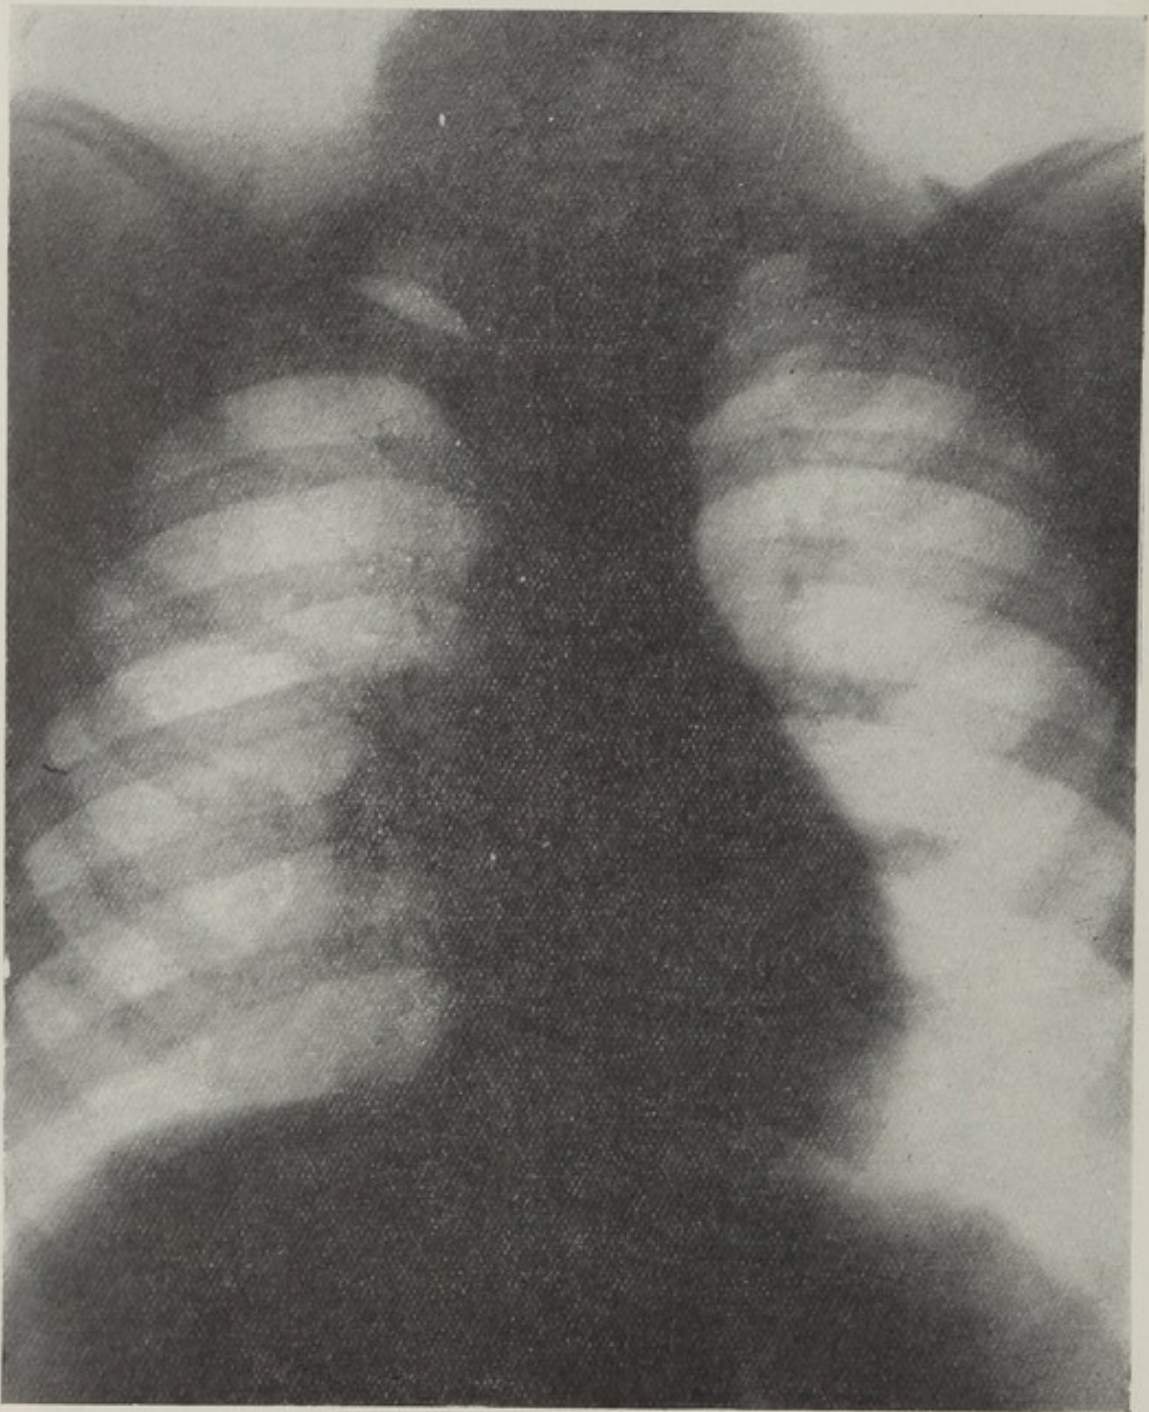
Unsuspected hilar lesion; the patient complained of no symptoms, and the condition was discovered radiographically.
